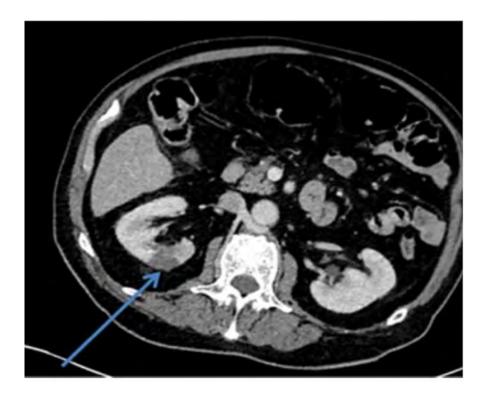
CT-arterial portography.
